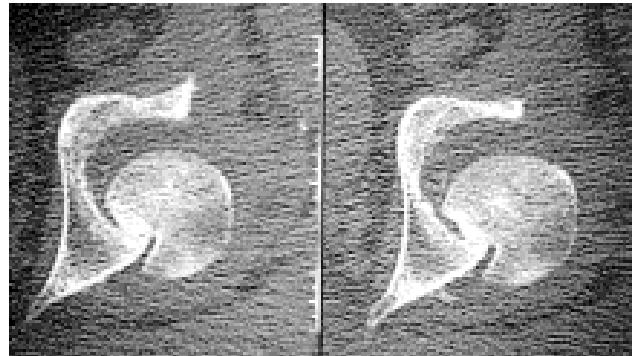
Computed tomography scan images at the level of the left hip joint demonstrating the wedge-shaped defect in the anteromedial aspect of the femoral head caused by impaction on the posterior acetabular rim.
